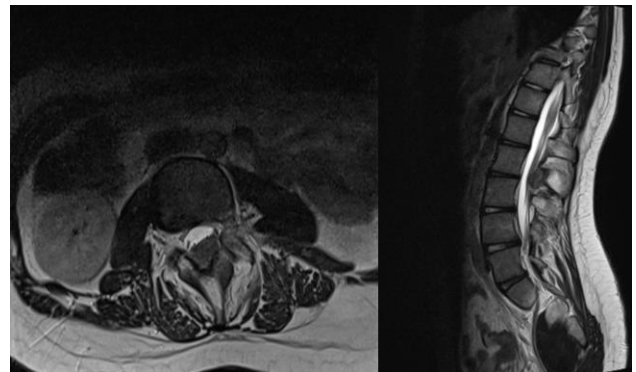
T2 weighted MRI image of lumbosacral spine
